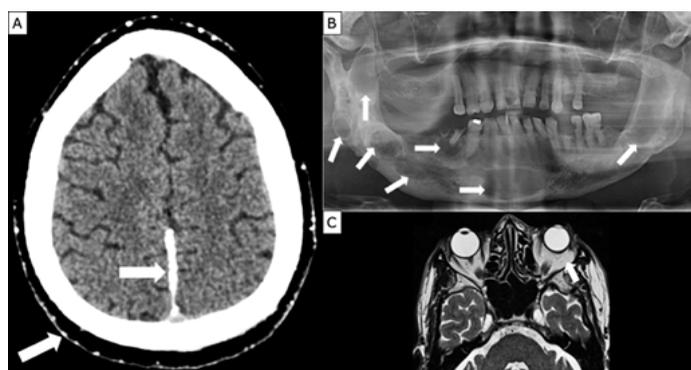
Imaging studies. A) brain computed tomography scan showing calcifications in falx cerebri and tentorium cerebelli; B) orthopantomography indicating multiple lesions in mandibular body and branch; C) gadolinium-enhanced magnetic resonance showing orbits (left subconjunctival infraorbital fat involvement is observed).
